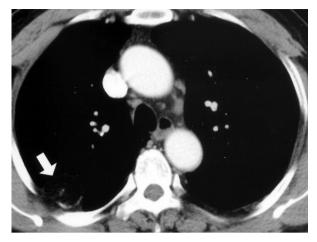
Computed tomographic scan (mediastinum window, contrast phase) reveals the lesion is hypodense in nature with calcified capsule
